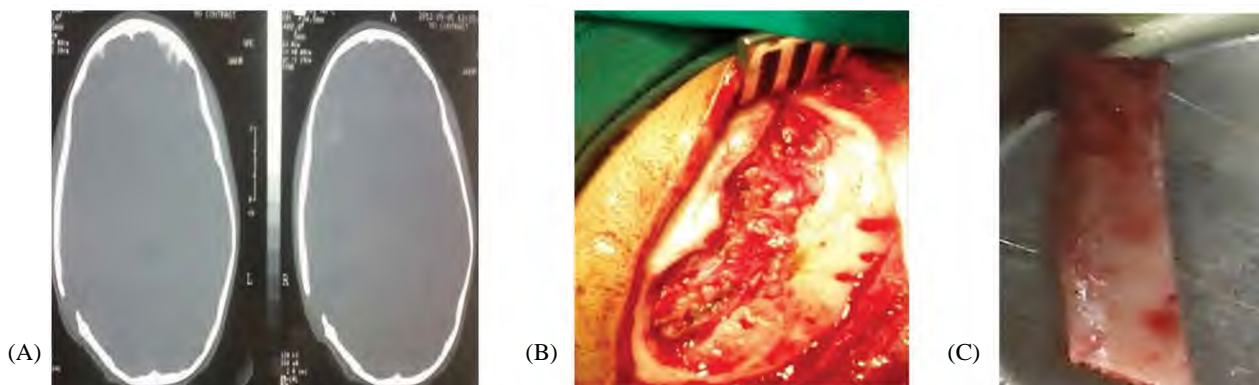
(A) Pre-operative CT showing the defect. (B) Intra-operative image of the defect with freshening of edges. (C) Image of the rib graft used for cranioplasty.
